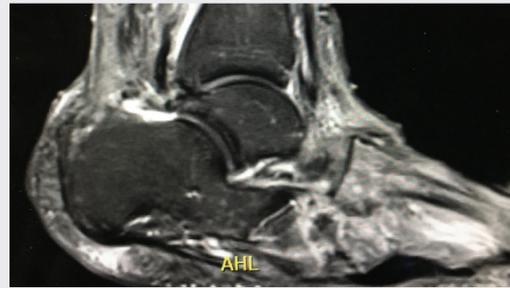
MRI findings compatible with osteomyelitis.
